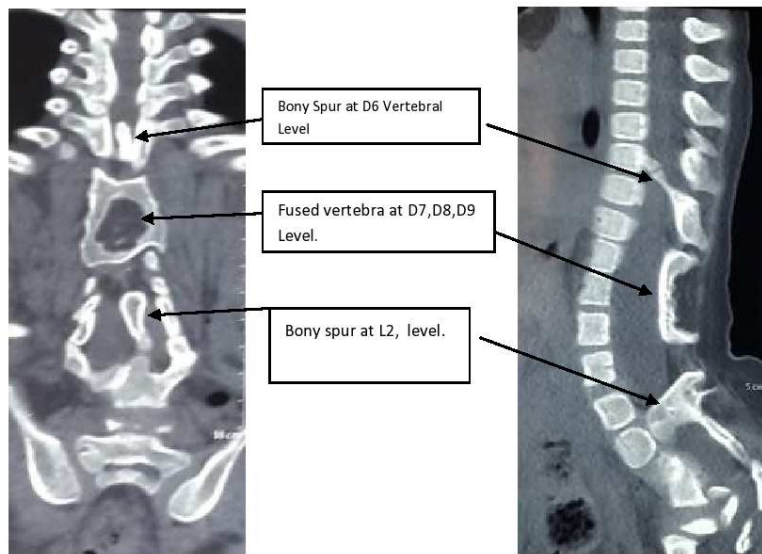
Coronal and sagittal CT whole spine
